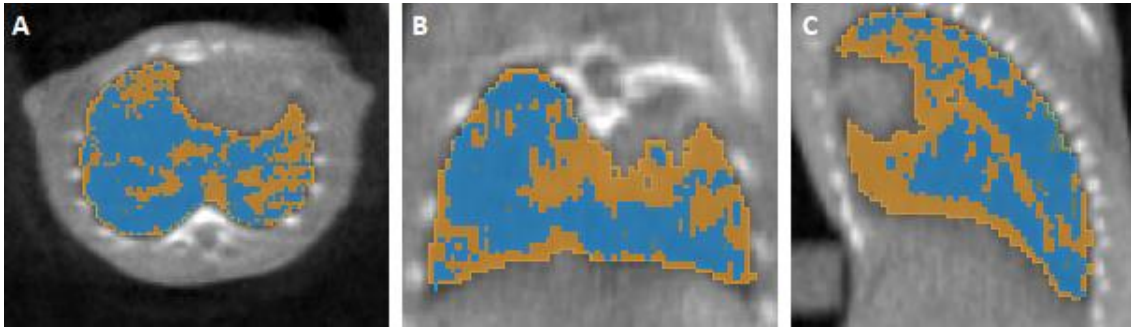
CT scan showing ROIs of the normo-aerated (blue) and poorly aerated (orange) lung volumes in the axial (A), sagittal (B) and coronal (C) views.
